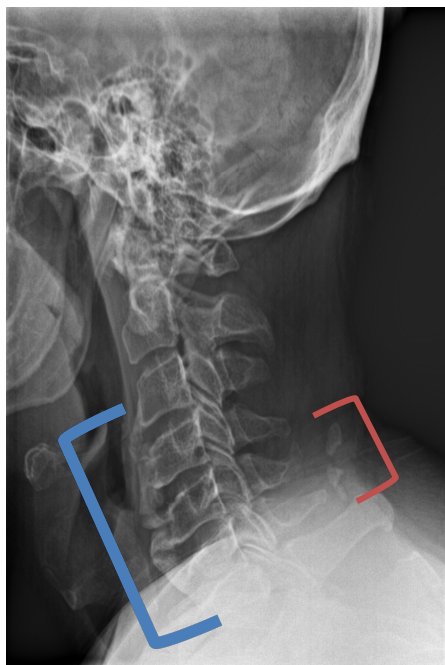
Lateral cervical radiograph demonstrating ossification of the anterior longitudinal ligament from C3-C7 (blue bracket), nuchal ligament ossification at C5 and C6 (orange bracket), relatively preserved disc spaces and osteophytes.
